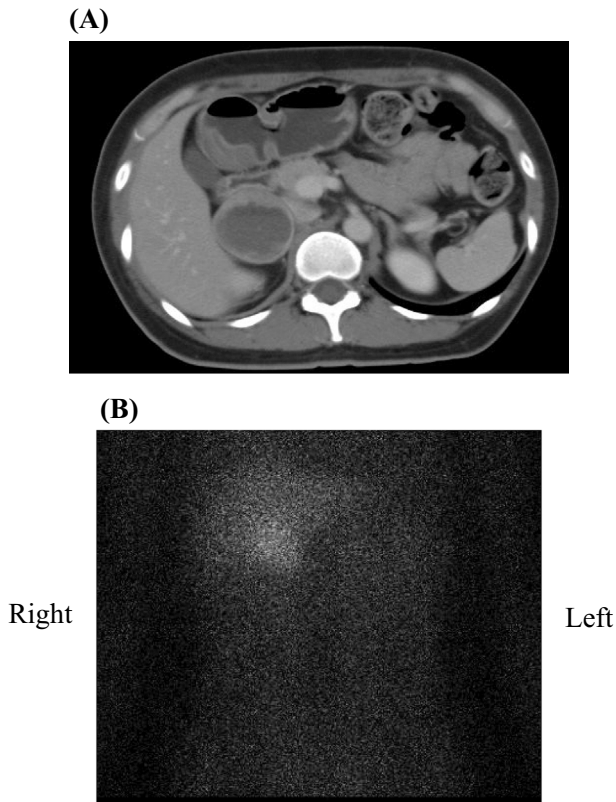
Computed tomography and iodine-131-meta-iodobenzylguanidine (MIBG) scintigraphy. (A) Abdominal computed tomography showing a huge right adrenal tumor, covered by a film, and with a heterogeneous internal structure. (B) MIBG scintigraphy showing an area of accumulation in the right adrenal tumor.
